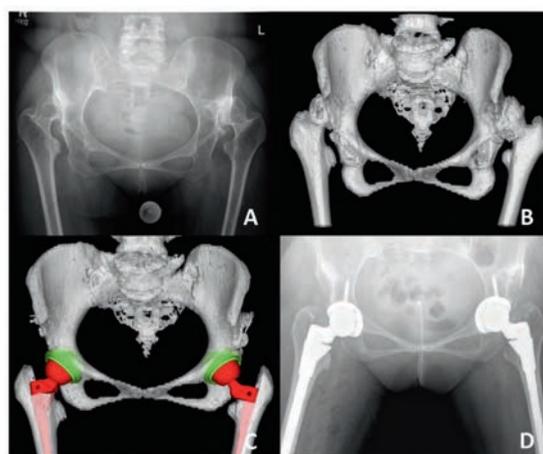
Another case using 3D-CT for complex hip arthroplasty. A) This is a case of bilateral Crowe Grade IV DDH in a 54 year old woman who was finding walking increasingly difficult. B) A pelvis model was created to gain a better appreciation of her unique anatomy and deformity. C) The components chosen were S-ROM ceramic-on-poly Pinnacle hip replacements. D) The plan was achieved with almost perfect symmetrical reconstruction of hip centre of rotation, horizontal and vertical femoral offsets, and angular orientation of both cups and stems.
